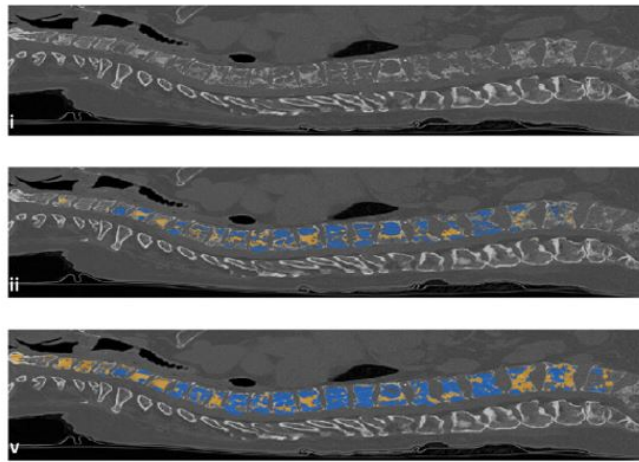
Results obtained by Chmelik et al. Image i) is the original CT acquisition, ii) is the segmentation done by a radiologist and v) the final result obtained by the automatic algorithm. Image adapted from [24].
